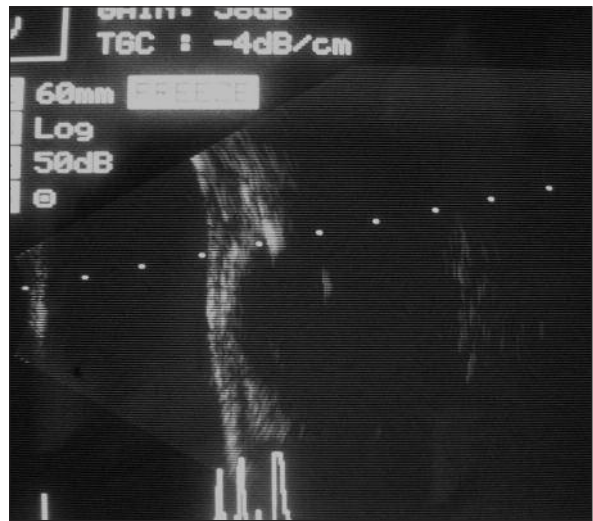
B-scan ultrasonography shows the highly reflective foreign body anterior to the lens (in a location corresponding to the anterior surface of the iris).
